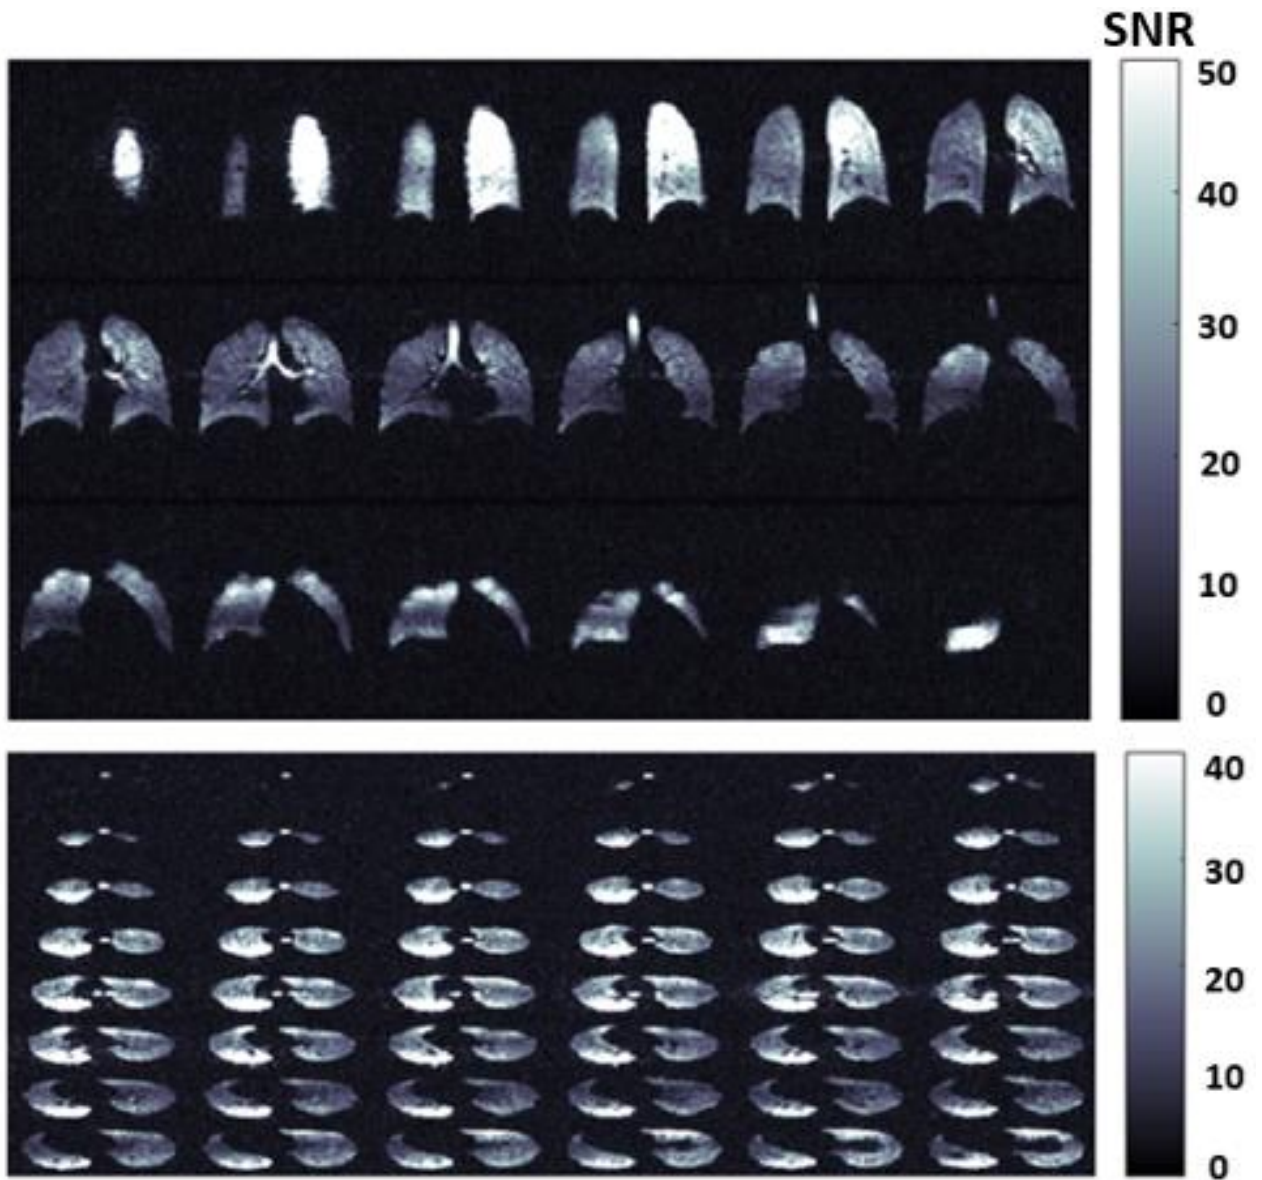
A: Lung ventilation Hyperpolarised¹²⁹Xe MR imaging acquired with the vest coil as transmission coil and 8-channel as a receiver.
